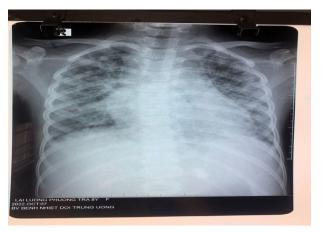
X-ray of the lungs (Oct 7.2022)
